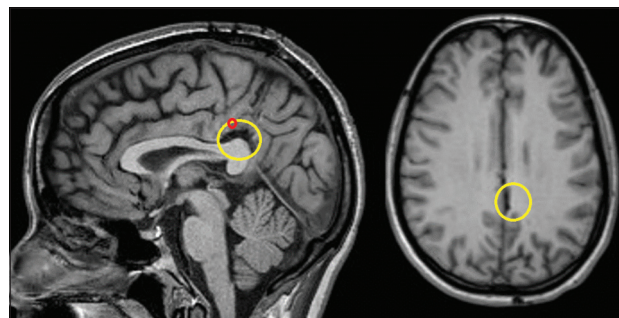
The second preoperative MRI. We retrospectively identified a discrete change on MRI (yellow circle). The position of seizure onsets is marked by red dots.
